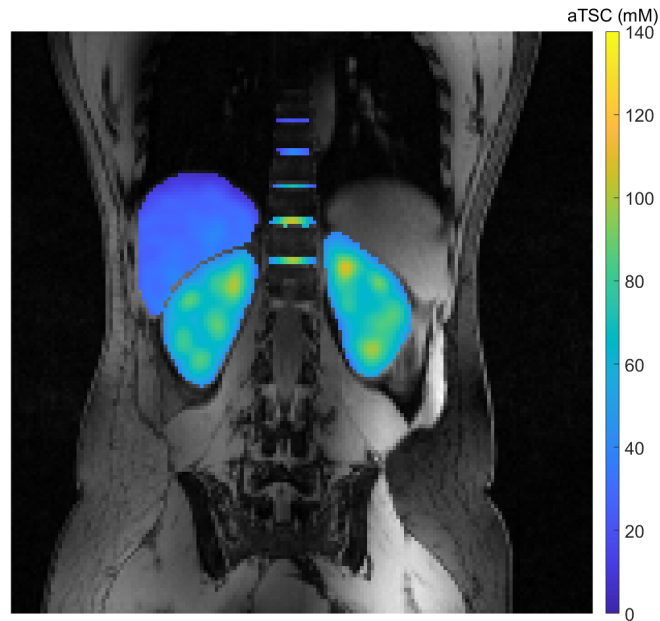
Exemplary visualization of the liver, kidney and a subset of the IVD masks for volunteer two. ^1H MR image are not displayed in the masked regions to allow a visual assessment of the aTSC for the depicted organs and IVDs.
